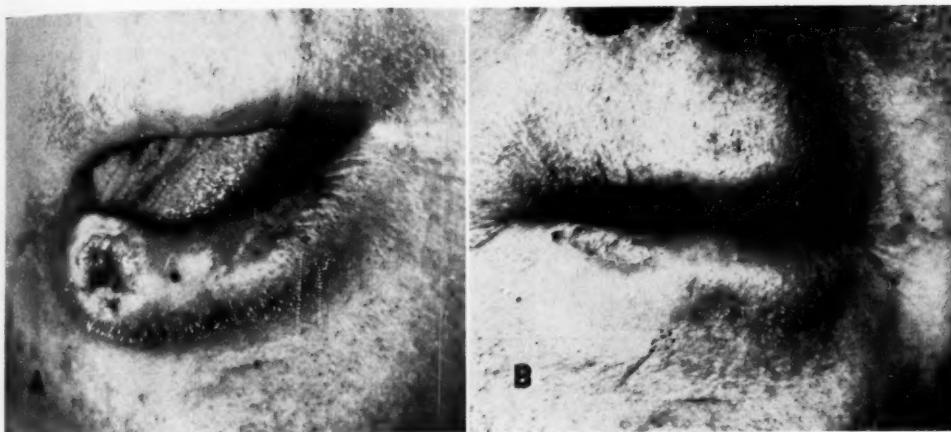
Ulcerated carcinoma of the vermillion border of the lower lip. A. Before treatment. B. After roentgen therapy.
